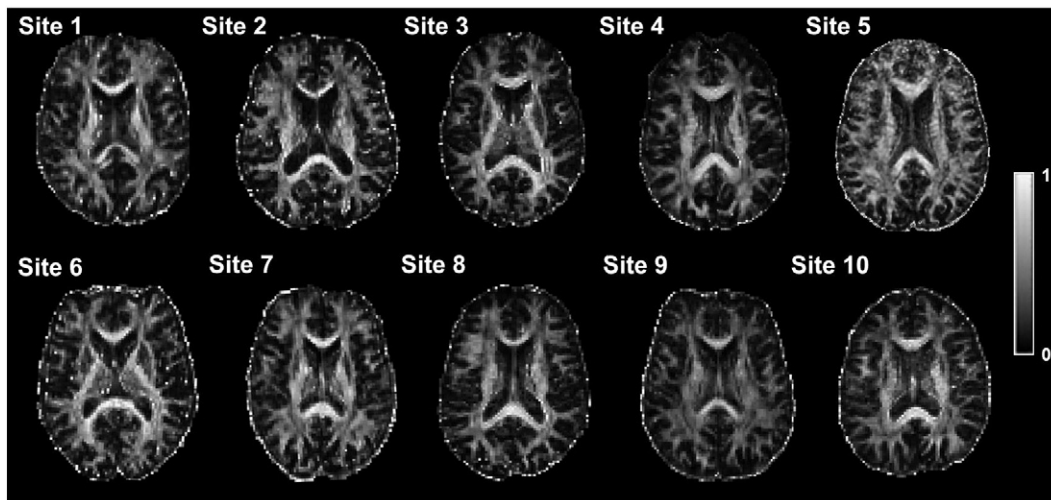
Sample single-subject FA maps across different 3 T MRI sites for qualitative comparison. See Table 2 for MRI sites characteristics.
